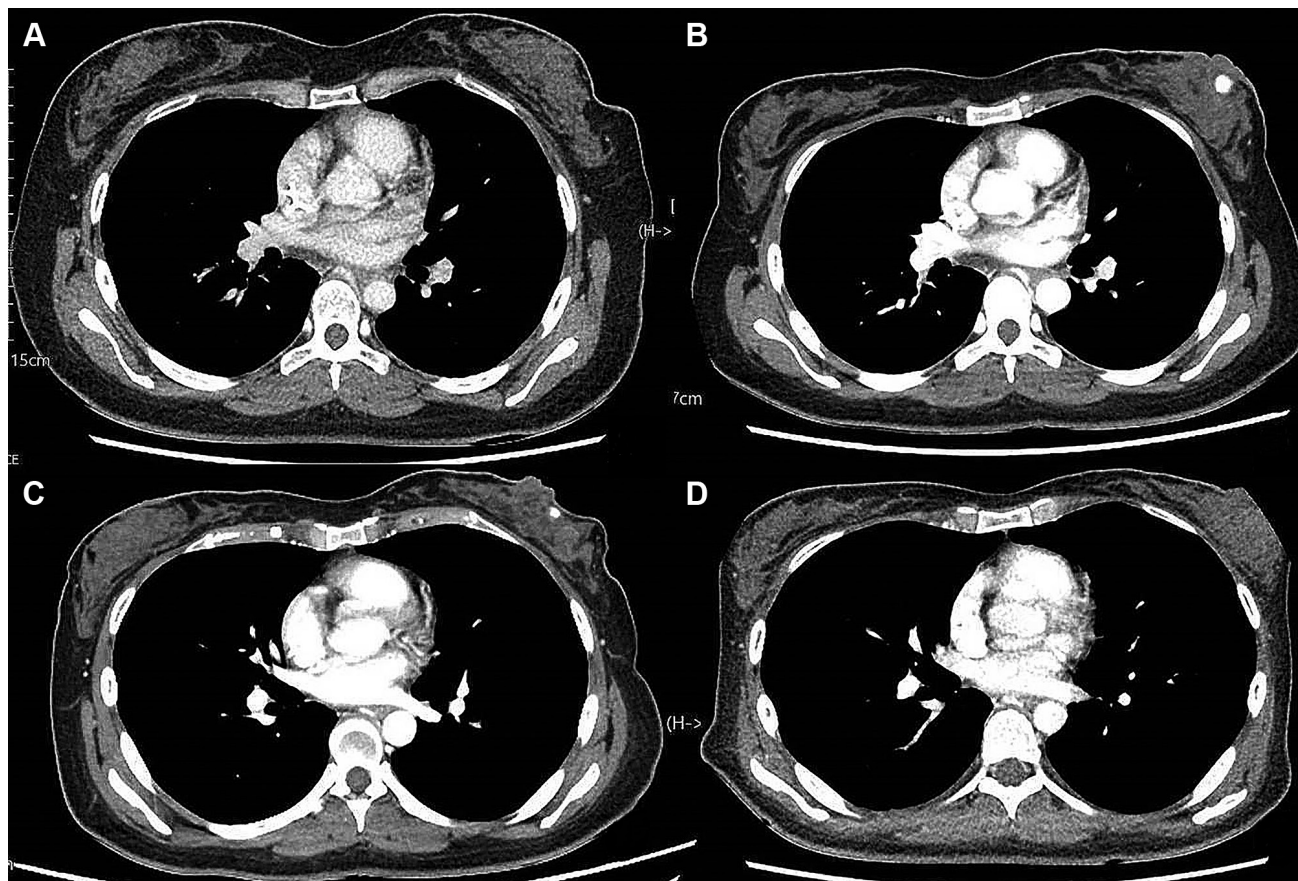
Chest computed tomography findings during treatment. (A) Chest computed tomography (CT) performed at the time of disease progression after first-line chemotherapy shows no remarkable findings in the left breast parenchyma. (B) A response evaluation CT after two cycles of second-line chemotherapy (paclitaxel plus ramucirumab) shows an enhanced nodule within the left breast parenchyma. (C) Follow-up CT performed two months after discontinuation of ramucirumab shows that the size of the hypervascular nodule has reduced. (D) Final chest CT obtained two months after (C) shows that the entire left breast could not be fully visualized; however, no hypervascular nodule can be identified in the visible portion.
